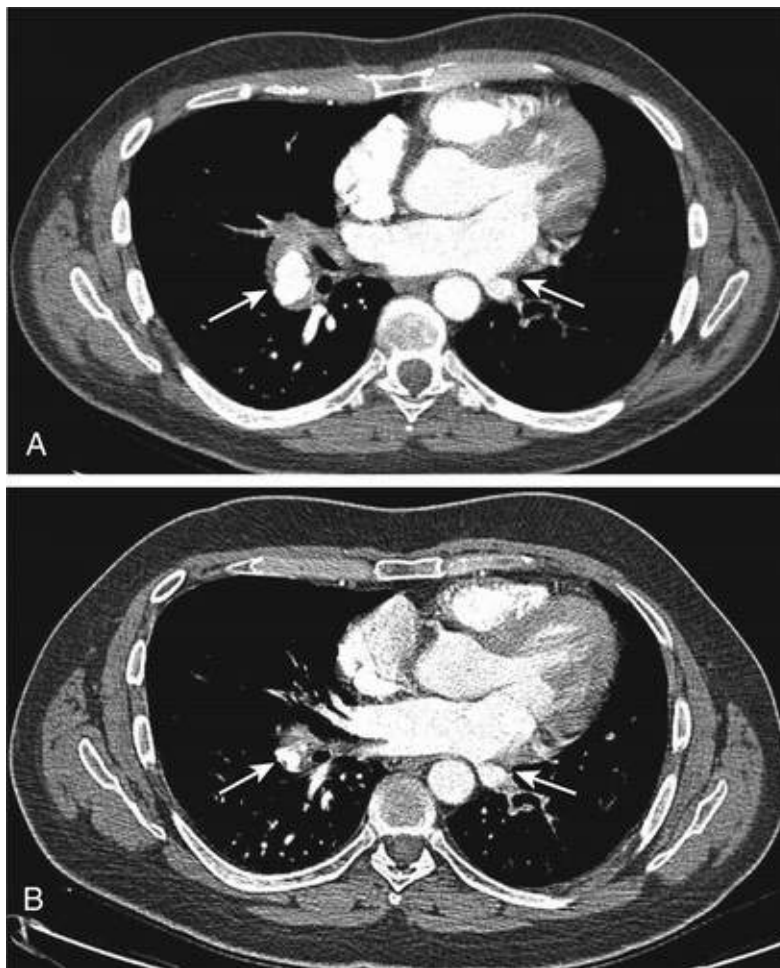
A, CT angiogram of a patient with Behçet disease showing bilateral pulmonary artery aneurysms (*arrows*). B, Following 4 months of treatment with the TNF- α antagonist infliximab, some reduction in the size of the pulmonary aneurysm on the right is seen. (Courtesy Professor Dorian Haskard, National Heart and Lung Institute, Imperial College, London.)
